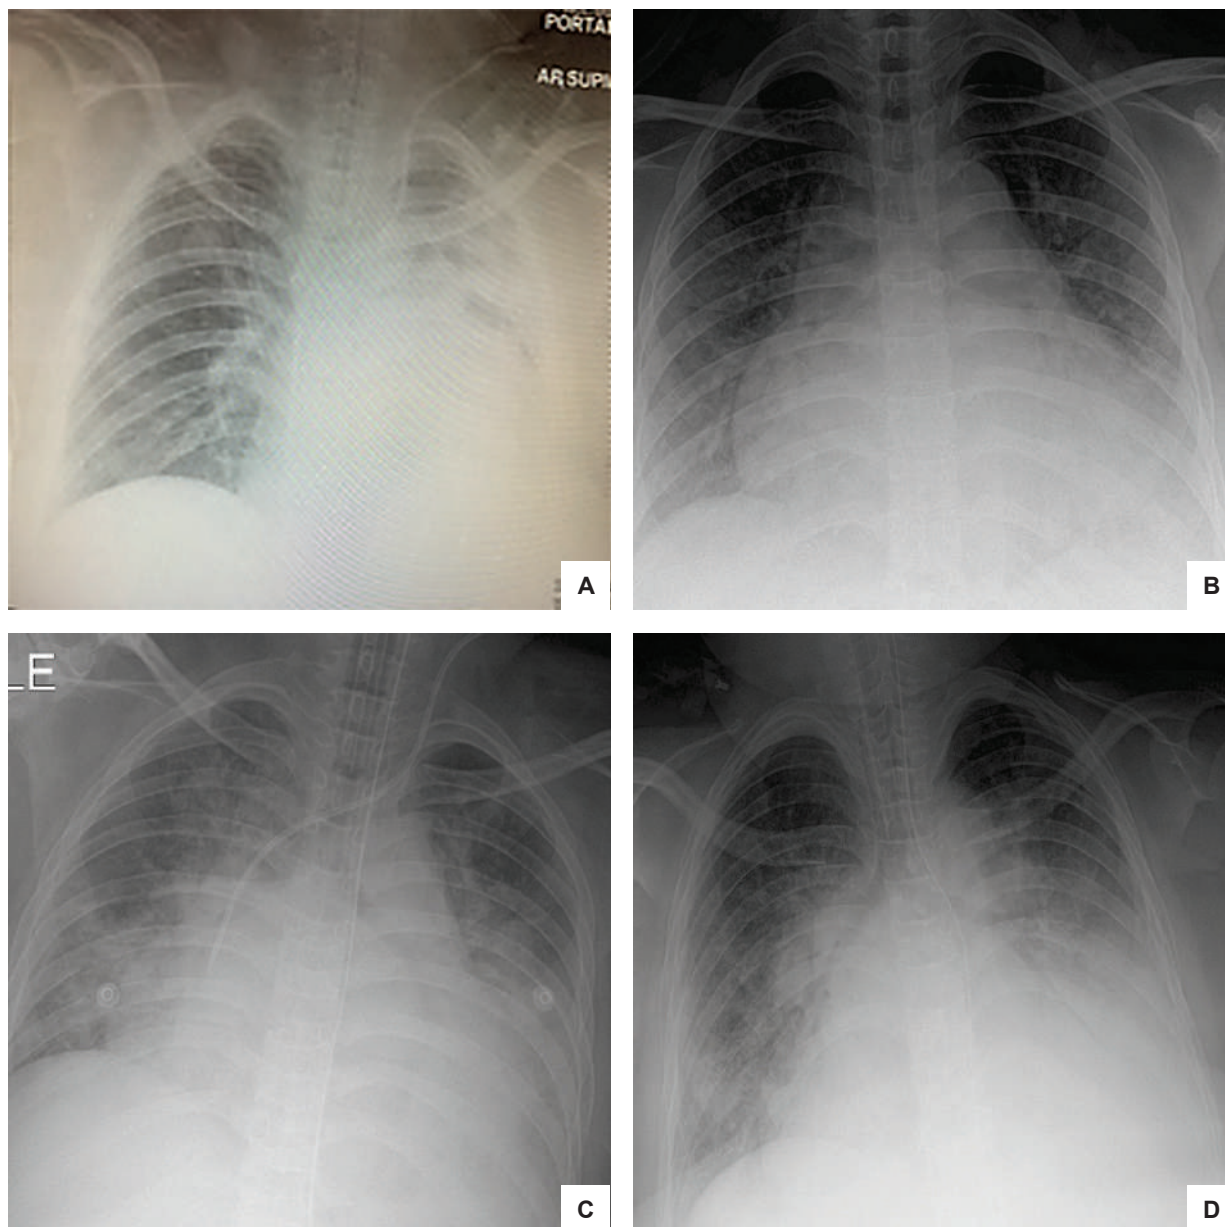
Serial chest radiographs showing acute pulmonary oedema from her previous 4 admissions. (A) left pleural effusion with bat's wings appearance and cardiomegaly; (B) left pleural effusion with cardiomegaly; (C) upper lobe diversion with bat's wings appearance and cardiomegaly; (D) left pleural effusion.
